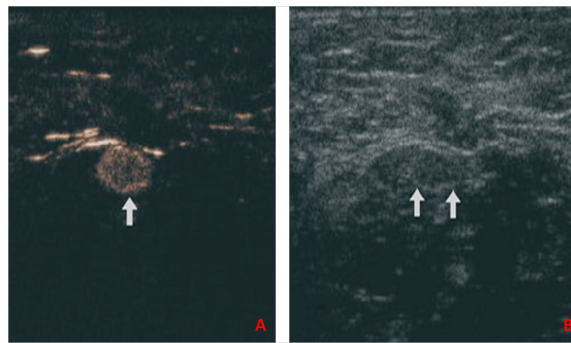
Example of lymphatic mapping with contrast-enhanced ultrasound. (A) Image of axilla showing lymphatics and a sentinel lymph node (arrow). Image was captured in special ultrasound modality called contrast pulse sequencing that allows enhancement of contrast-media. (B) B-mode ultrasound image shows a lymph node (arrows) in the area of major contrast confirming that the contrast-agent accumulation succeeds in such. Image reproduced with permission of John Wiley and Sons Ltd from [300].
